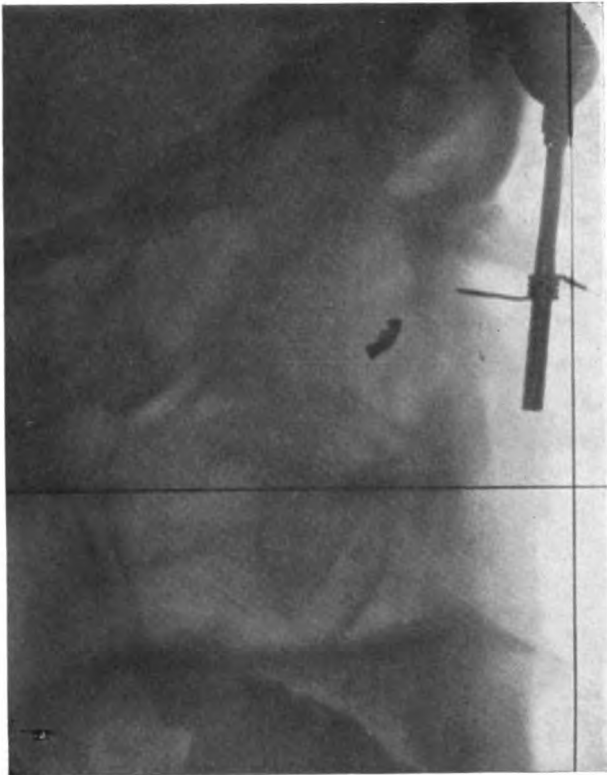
Radiograph by Dr. Dixon localizing foreign body in the eye.
